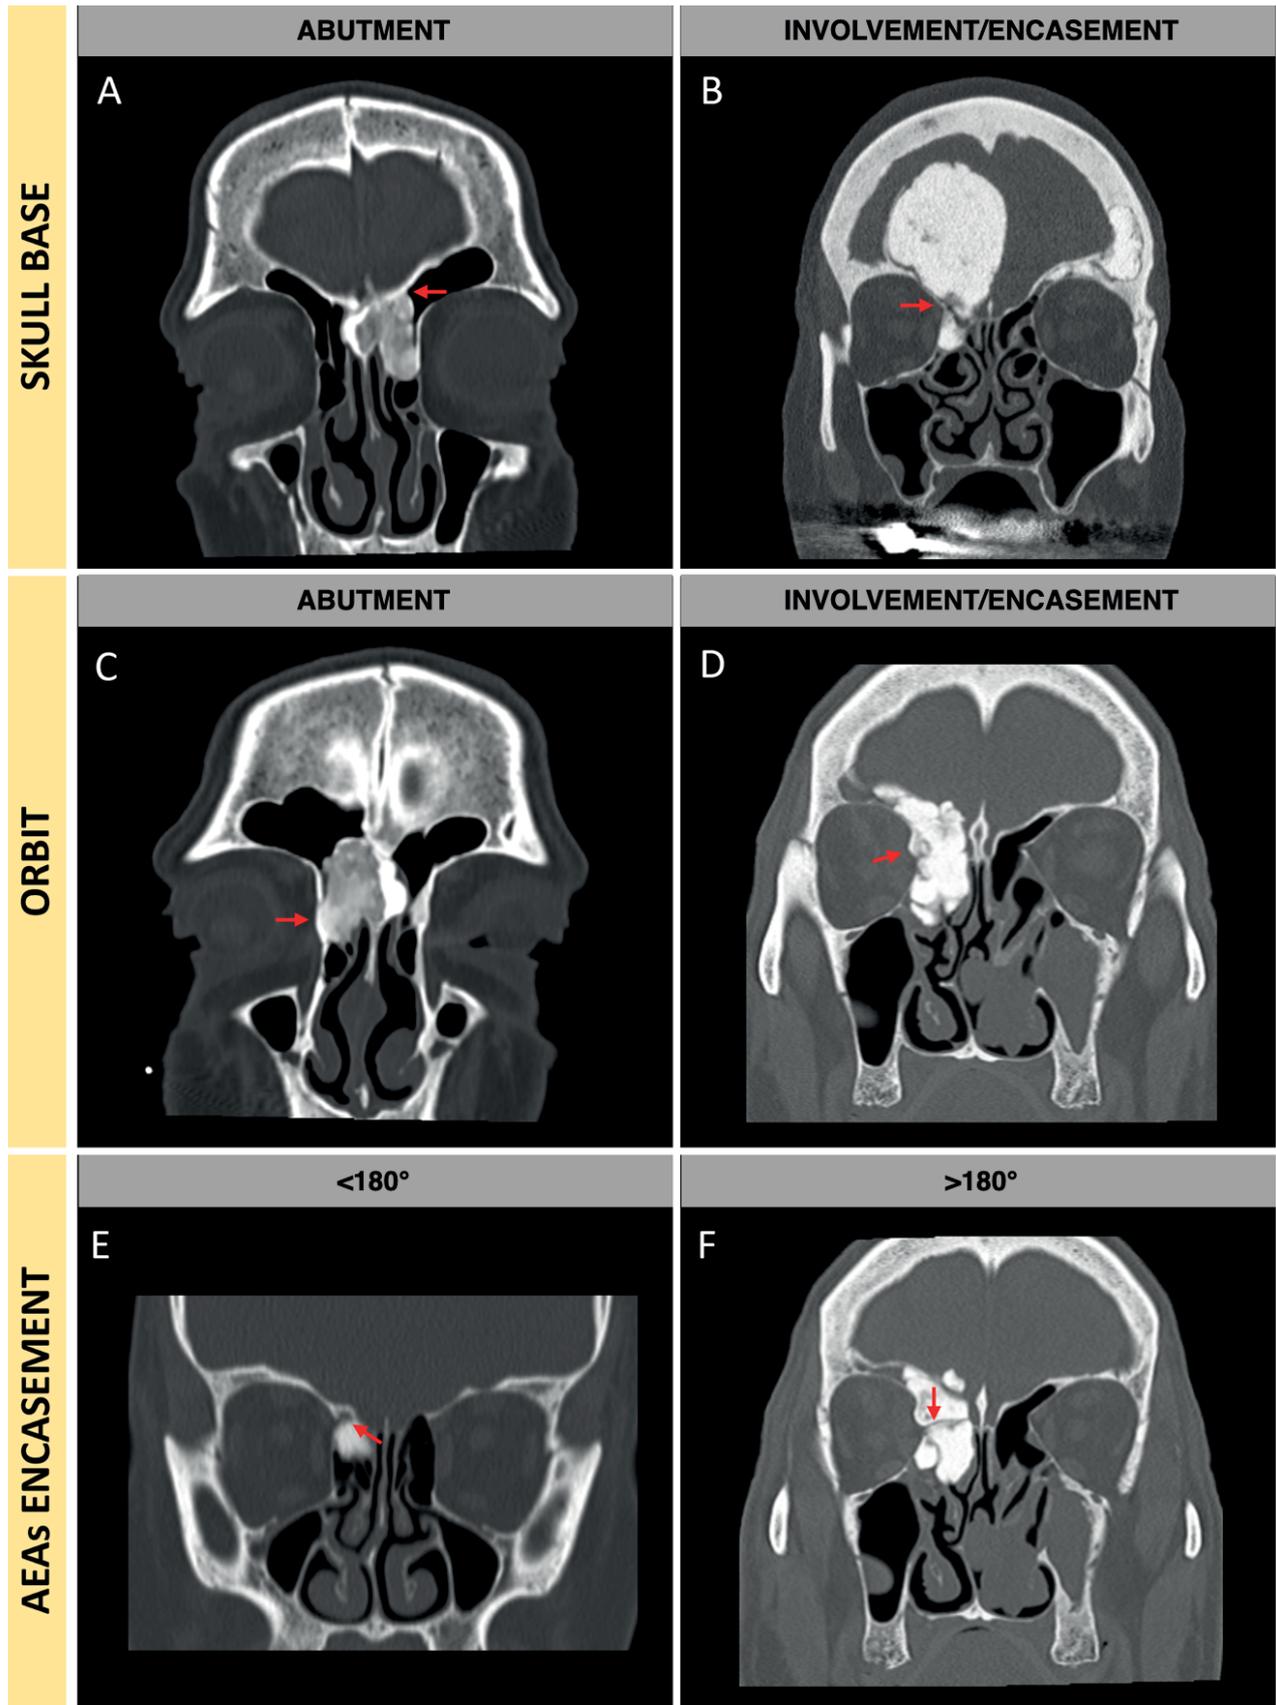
CT-scan imaging showing osteomas' radiological relationships (red arrows) with critical structures: osteomas in abutment (A) and involvement/encasement (B) of the anterior skull base; osteomas in abutment (C) and involvement/encasement (D) the papyrcea; osteomas encasing <180° (E) or >180 (F) the anterior ethmoidal artery.
